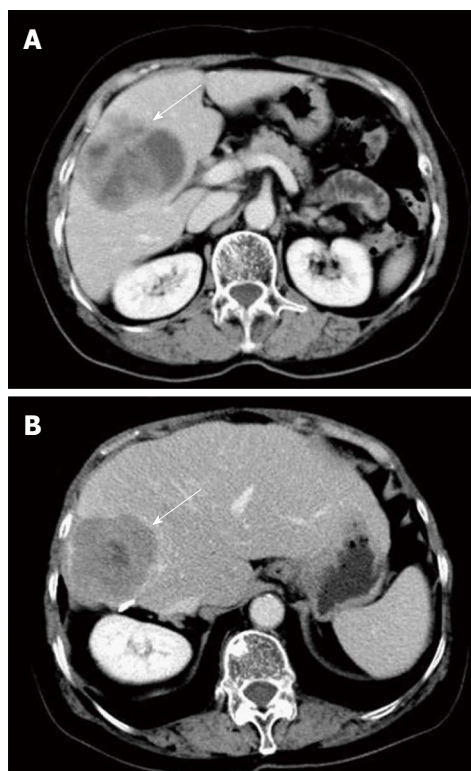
Computed tomography images of the tumor. A: An enhanced abdominal computed tomography (CT) scan from August 2009 showed a 7.4 cm \times 6.2 cm solid-cystic mass in the right hepatic lobe (venous phases in the axial plane). The central portion was of low-density with thickened irregular peripheral margins; B: An enhanced abdominal CT scan in September 2011 showed a 6 cm \times 5 cm solid-cystic mass in the residual right liver (venous phases in the axial plane).
